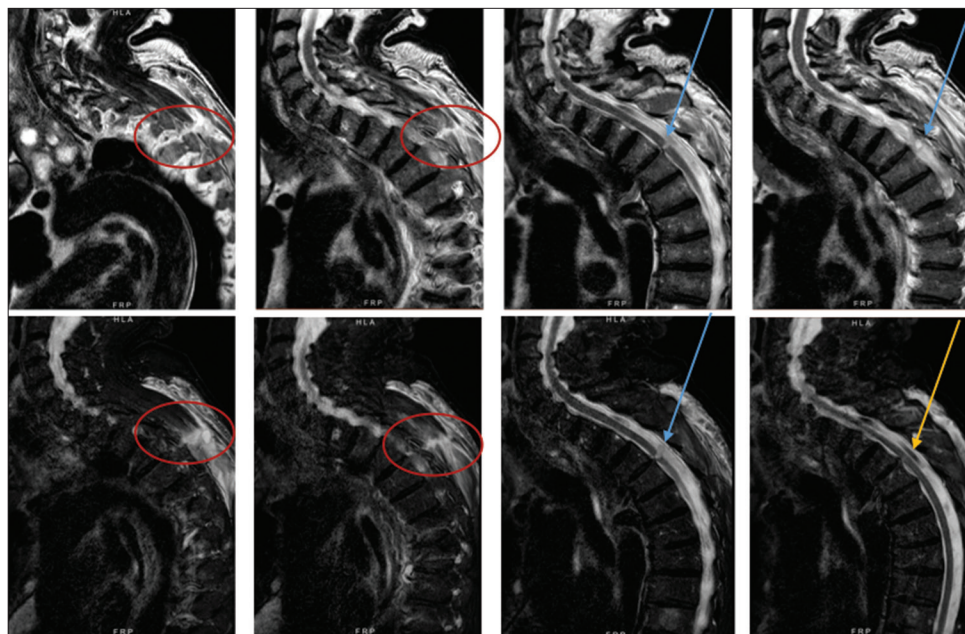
Spinal magnetic resonance imaging of patient 1. Upper row: sagittal slices, T2-weighted sequences. Lower row: sagittal slices, short-tau inversion recovery sequences. Red circles indicate a fracture of the articular facet and a laceration of the yellow ligament on the left. Blue arrows indicate the spinal cord lesion; yellow arrow indicates subdural hematoma.
